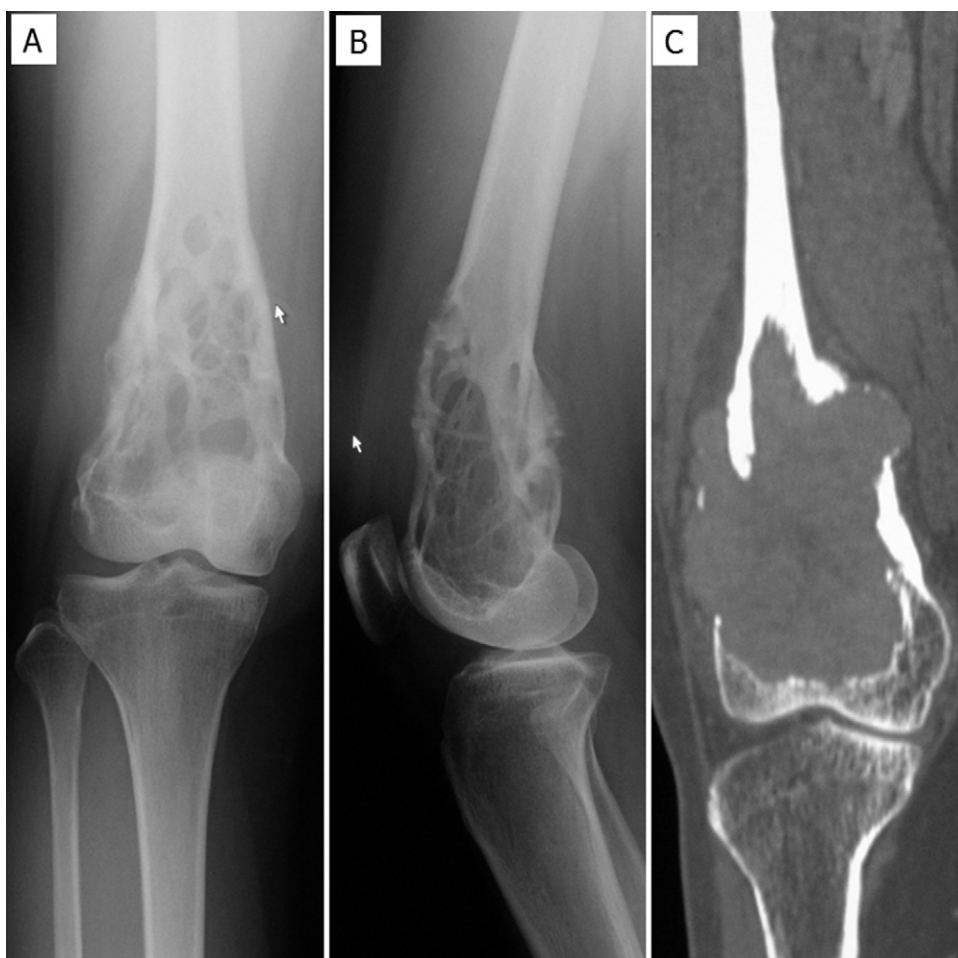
Plain radiograph showing a honeycombed lucent lesion on the right distal femur: (A) anterior-posterior view and (B) lateral view. Computed tomography scan showing a tumor partially destroying the cortex and extending into the surrounding soft tissue (C).
